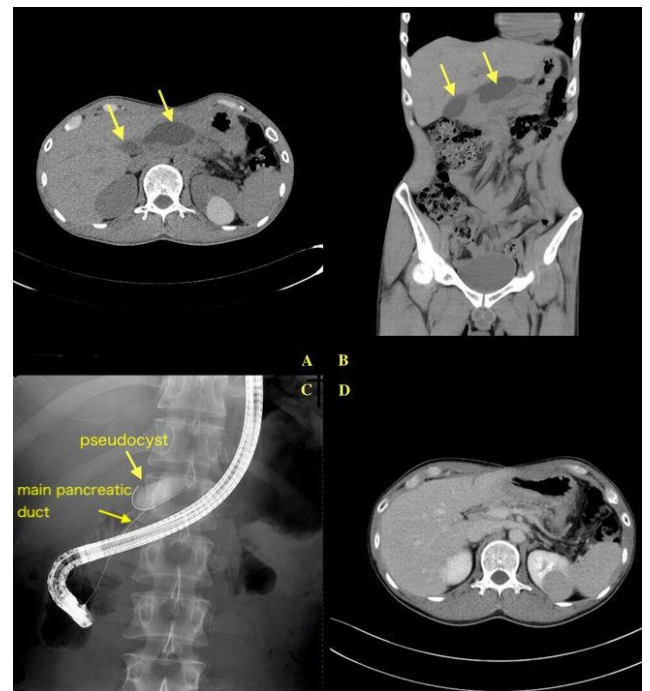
(A-B) A pancreatic pseudocyst appeared after removing left subphrenic ② drainage tube. (C): ERP finding. The connection between the pseudocyst and the main pancreatic duct was confirmed. (D): The CT finding after drainage by ERP tube.
